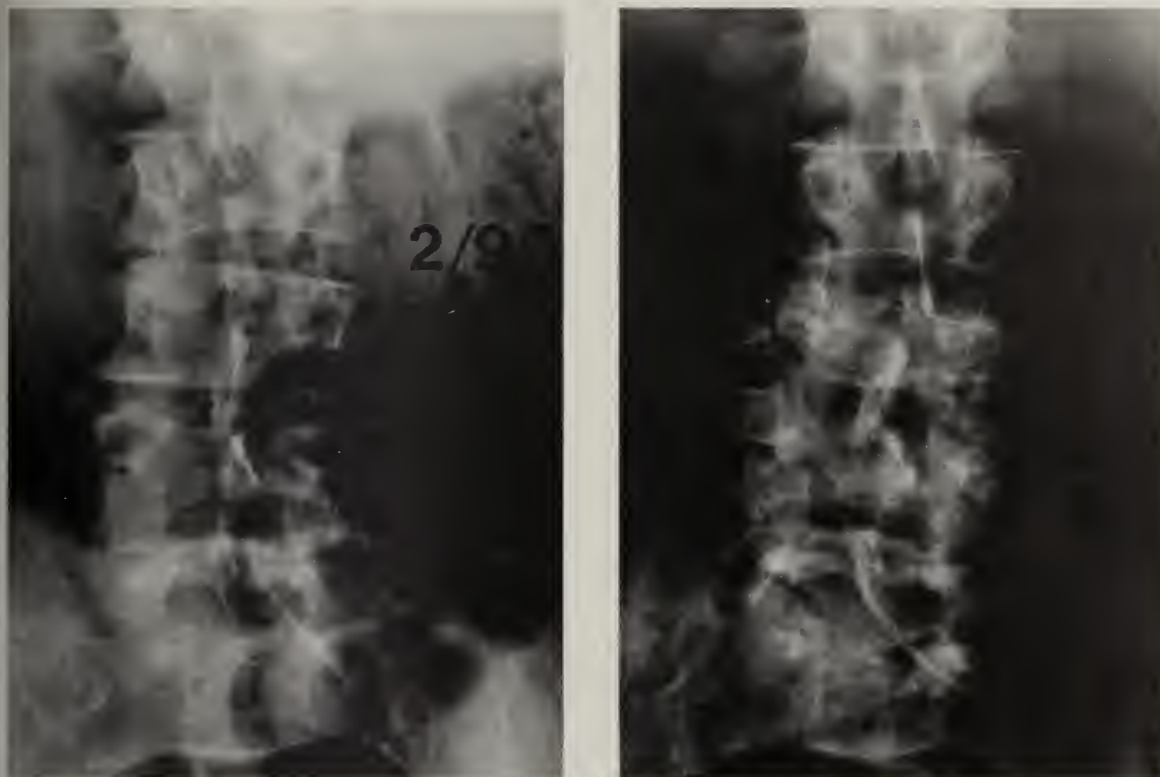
A and B. AP radiographs demonstrating progression of the spinal deformity during the 6-month period prior to presentation at the KDL Spine Center.
